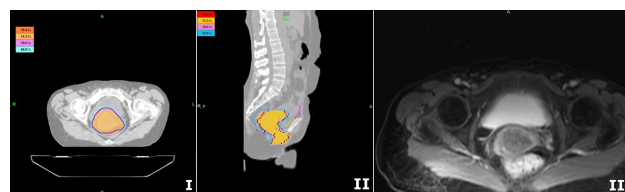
Stage IVa Cervix Ca. Axial (I), Sagittal (II) images of planning CT and T2 weighted MRI (III).
